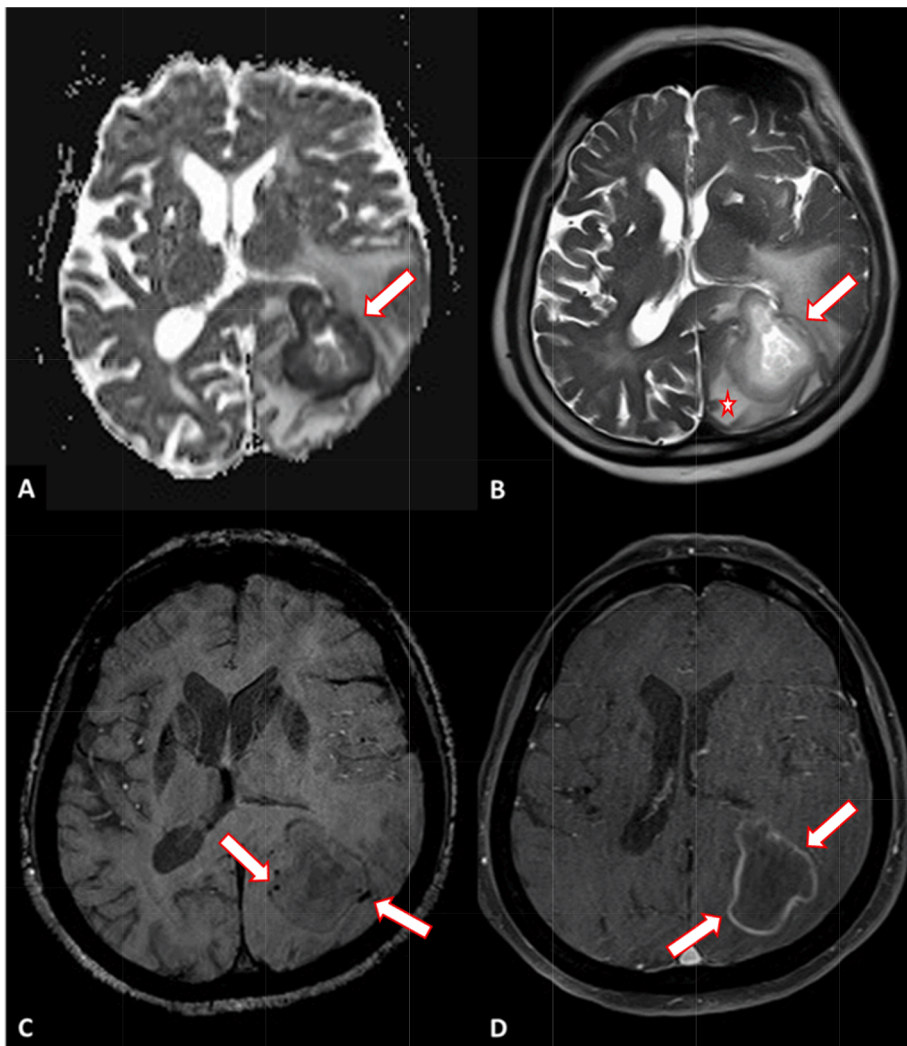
MRI demonstrates left parieto-occipital space occupying lesion. On DWI not shown, the lesion is intensely bright peripherally with corresponding very dark signal on ADC map (A) (red-white arrow) consistent with significant diffusion restriction. On T2 (B), the lesion demonstrates heterogenous signal intensity with hyperintensity centrally and intermediate signal peripherally with evidence of dark peripheral rim (red-white arrow) and surrounding vasogenic edema (red-white star). On SWI (C), the lesion demonstrates foci of susceptibility artefacts peripherally denoting hemorrhage/ paramagnetic products such as iron/magnesium (red-white arrows). On Sagittal axial T1 post contrast (D) the lesion demonstrates smooth thin peripheral rim of enhancement (red-white arrows).
